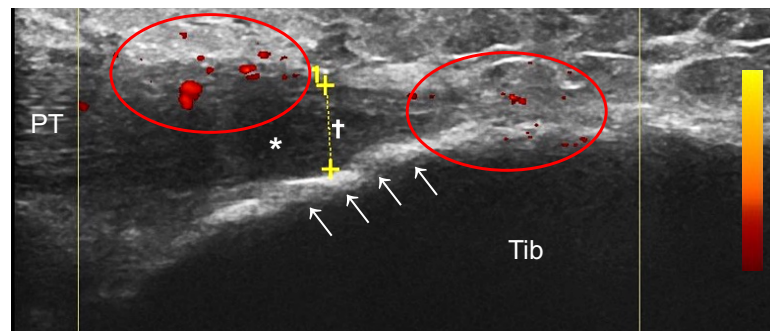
Left distal patella tendon demonstrating grey scale and power Doppler peritendonitis (circled, grade 1) in association with adjacent enthesal thickening (†, grade 2), hypoechogenicity (\*, grade 2), power Doppler signal (circled, grade 1), bone cortex irregularities and enthesophytes (↑, grade 2) in a patient with moderate to severe psoriasis. PT: Patellar tendon; Tib: Tibia.
